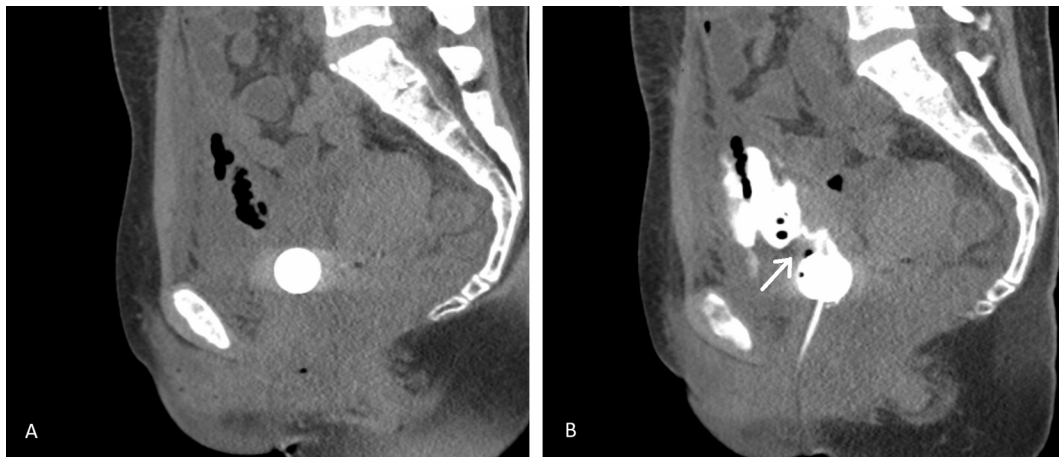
CT urogram with contrast demonstrating extraperitoneal leak. Anterior extraperitoneal leak demonstrated. Image A taken prior to instillation of contrast with air and fluid appreciated between the anterior peritoneum and fascia. Image B with instillation of contrast demonstrating 0.7 cm anterior, extraperitoneal rupture with contrast extravasation into the extraperitoneal space. Arrow indicating area of rupture from the bladder.
